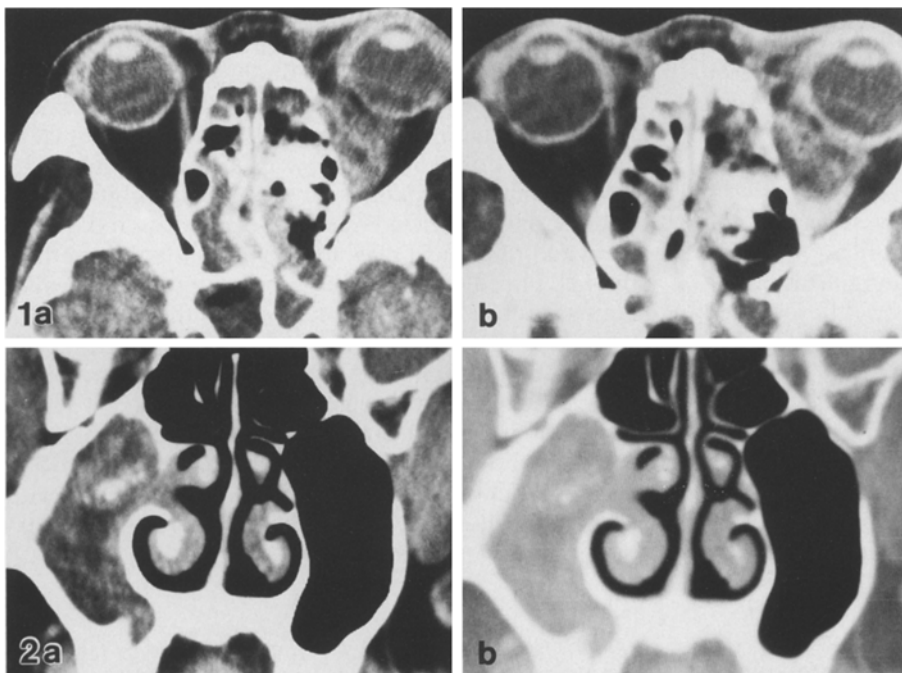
Case 1. A 62-year-old man with facial pain, general malaise and blood-tinged sputum for 3 months. Axial CT before (a) and after (b) intravenous contrast medium shows mass in the left ethmoid sinuses, with involvement of the orbit
